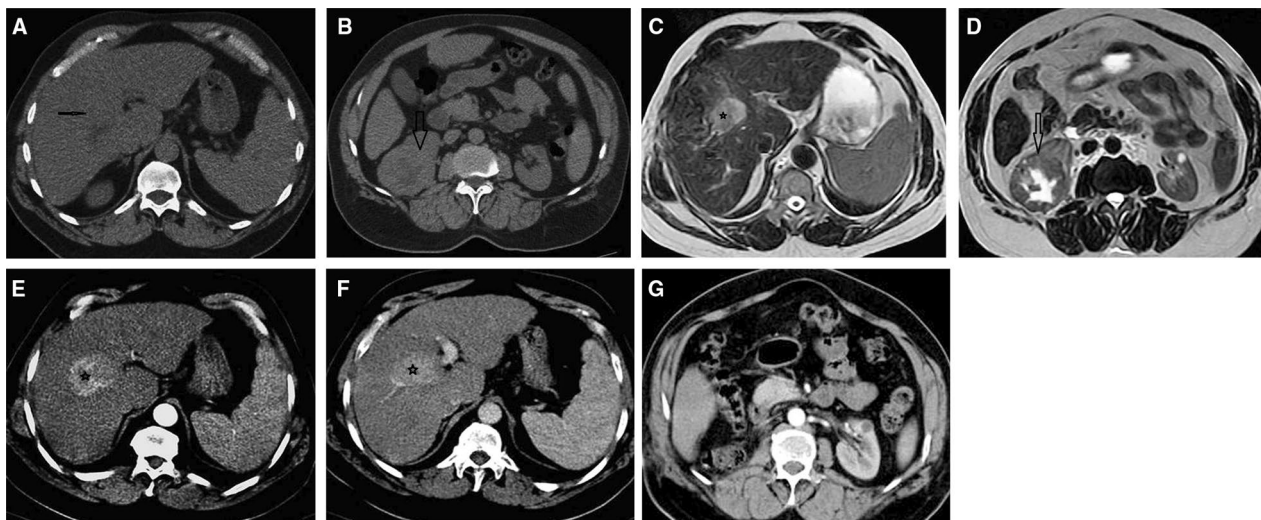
64-year-old male patient with a history of chronic liver disease presented with hematuria. a, b Initially, an unenhanced MDCT scan due to high serum creatinine (contra-indication for contrast study) revealed an ill-defined right liver lobe (thin arrow) and right renal mass (arrow). c, d T2 magnetic resonance image revealed hepatic focal lesion (star) (pathologically proved HCC) and right renal mass (arrow) (pathologically proved RCC). The patient underwent a right nephrectomy. e–g MDCT scan after nephrectomy showed right liver lobe mass (asterisk) with enhancement on arterial phase and washout in portal phase (characteristic of HCC) with right nephrectomy
